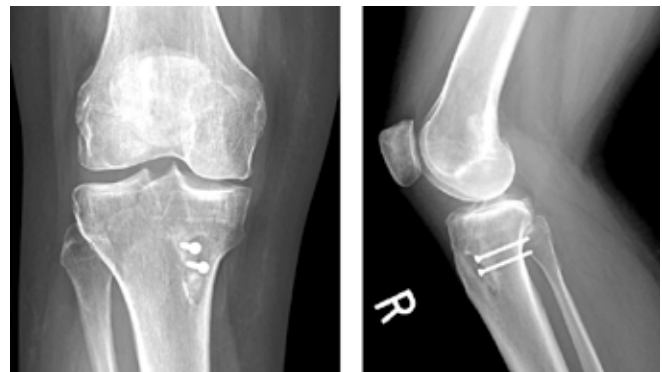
AP and lateral radiographs 7 months after right knee revision ACL reconstruction using compression screw fixation of the graft within the tibial tunnel.
